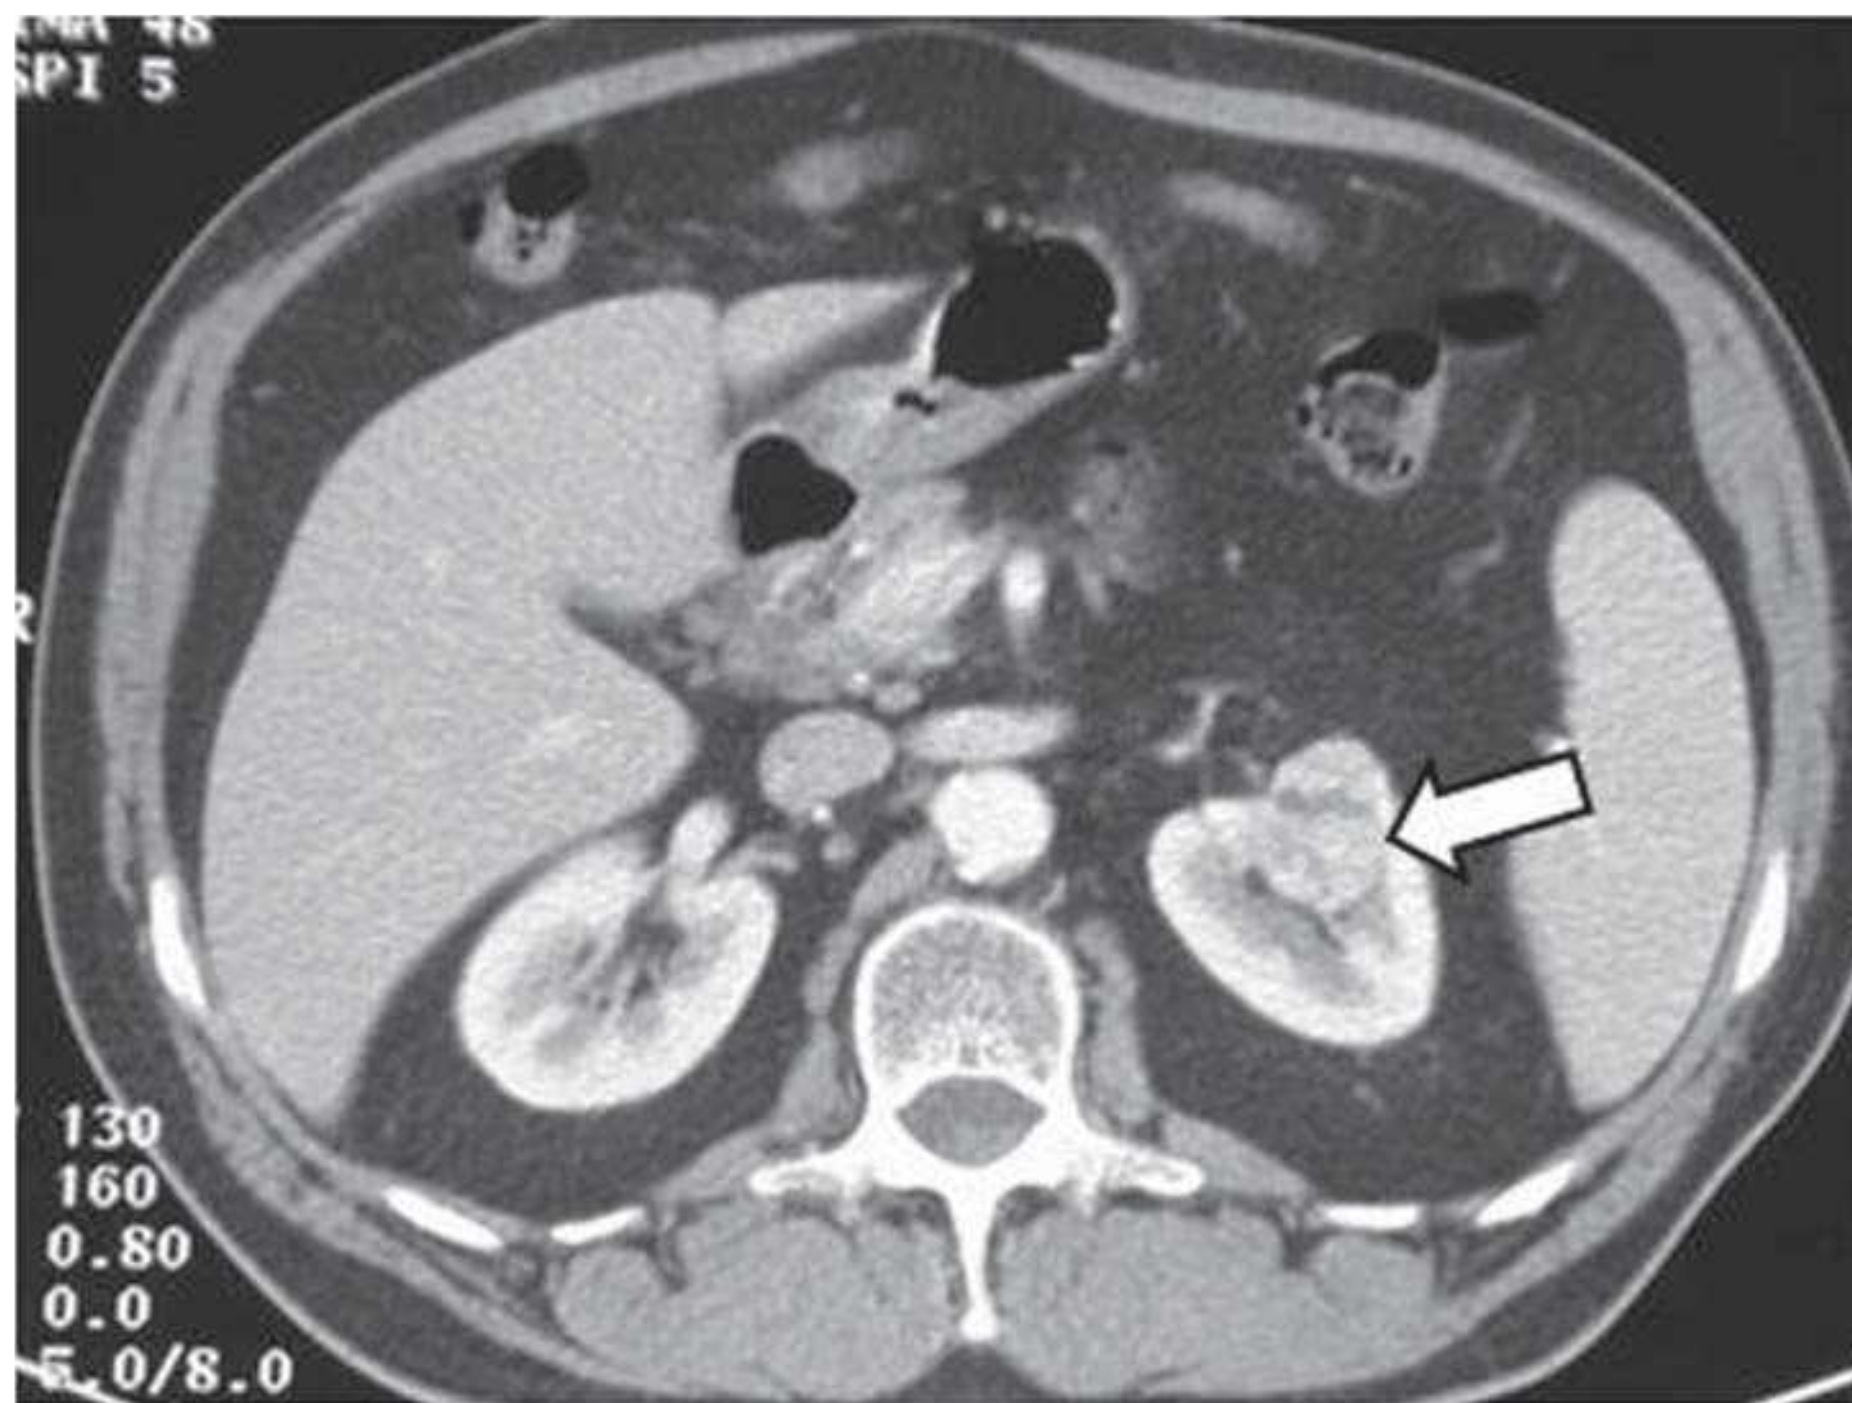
Contrast-enhanced CT showing an oncocytoma in the right kidney with mixed areas of enhancement and low attenuation. This is difficult to differentiate from renal cell cancer based on imaging alone.
